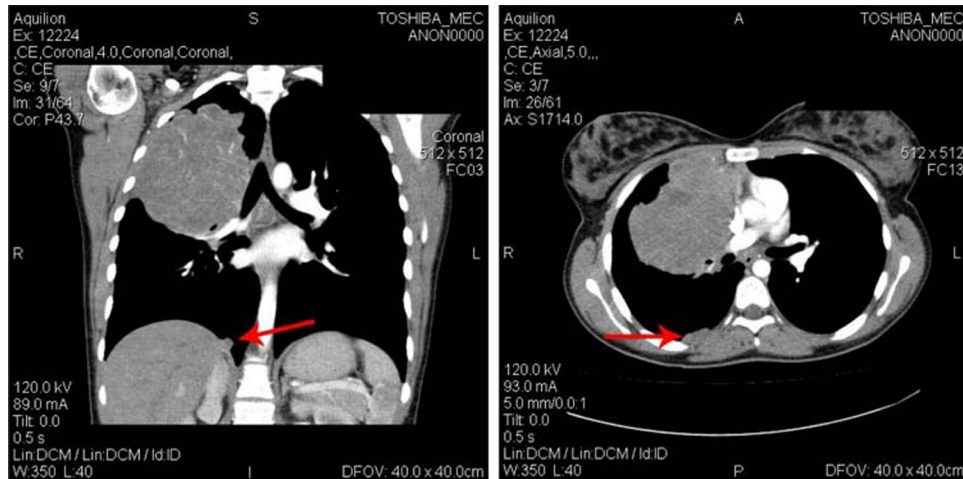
CT scan of chest demonstrating a 10.7×12.9 cm mass and pleural involvement.
